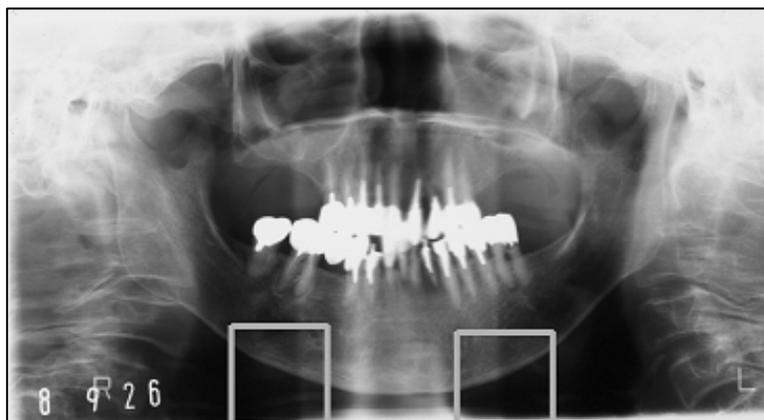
Dental panoramic radiograph.
